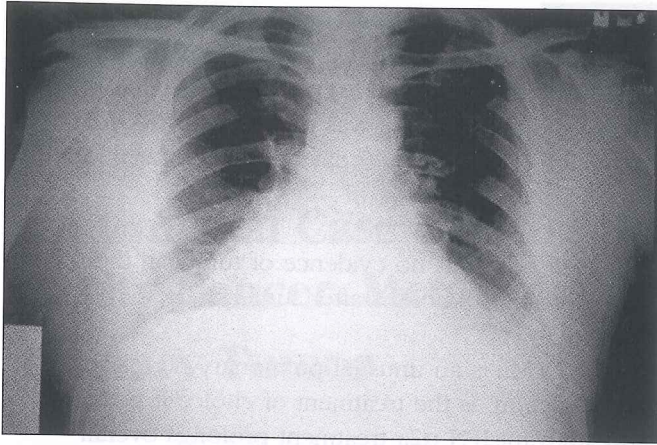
Chest radiograph shows right paracardial consolidation.
